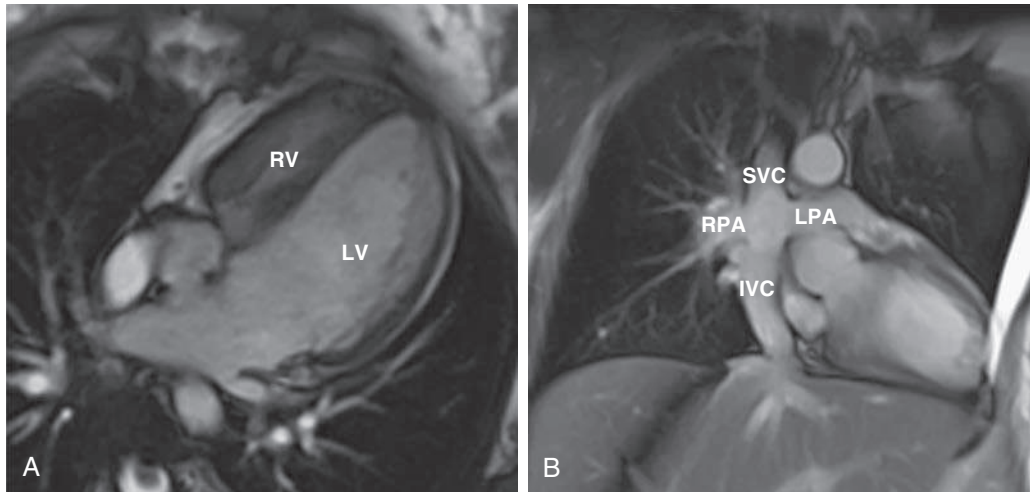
Magnetic resonance images of an adult patient with univentricular repair of pulmonary atresia with intact ventricular septum. A, “Four-chamber” balanced steady-state free precession (SSFP) image showing hypoplastic RV. The LV is normal size. B, Coronal image of total cavopulmonary connection (TCPC: superior vena cava [SVC] and inferior vena cava [IVC] anastomosed to pulmonary arteries) without obstruction.
